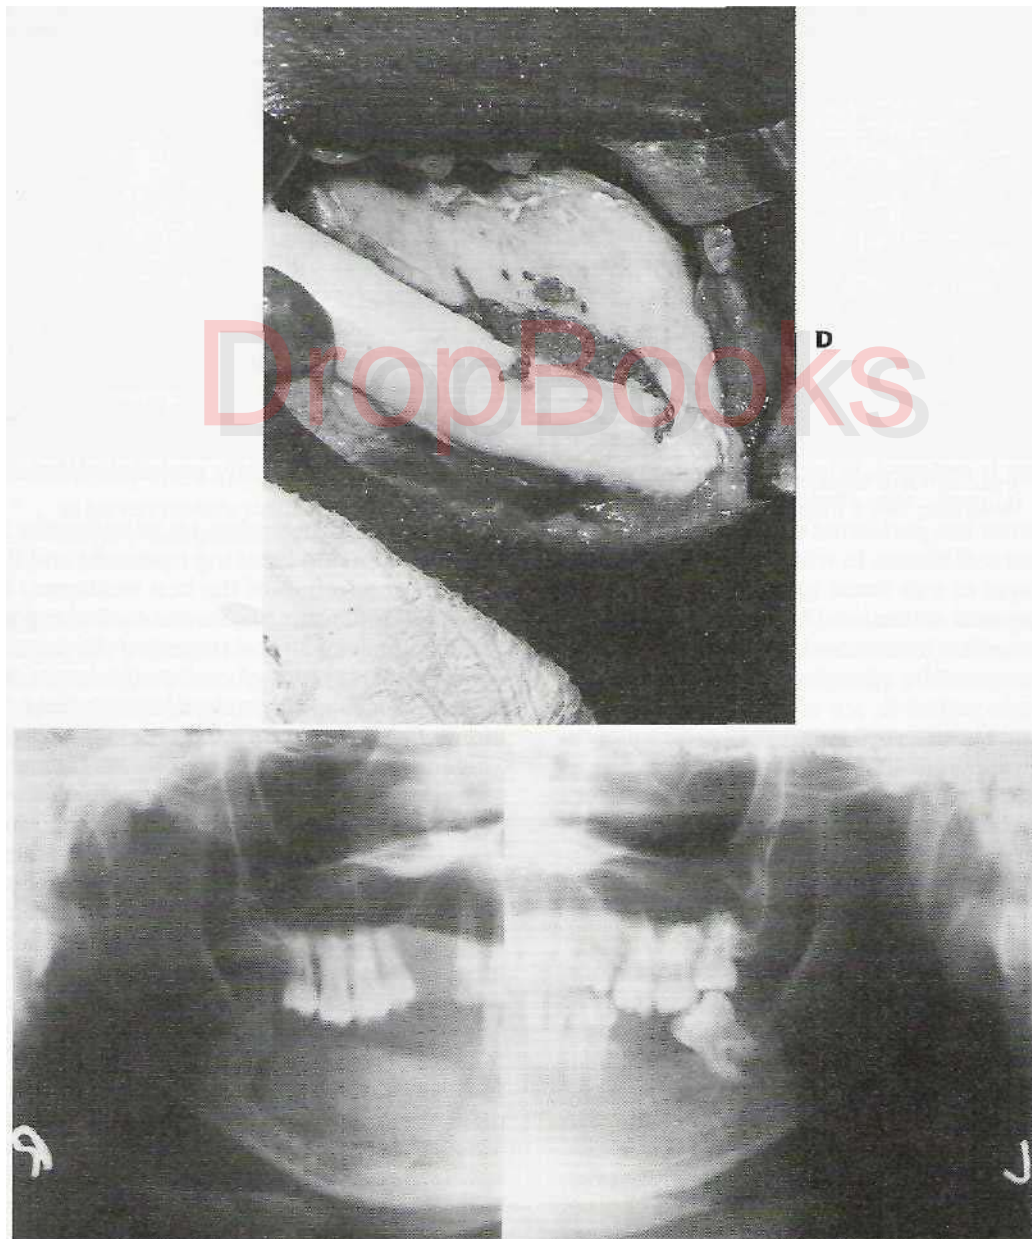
cont d D, Extraoral exposure and placement of bone graft to reconstruct mandibular alveolus. E, Radiographic appearance immediately after graft placement.
